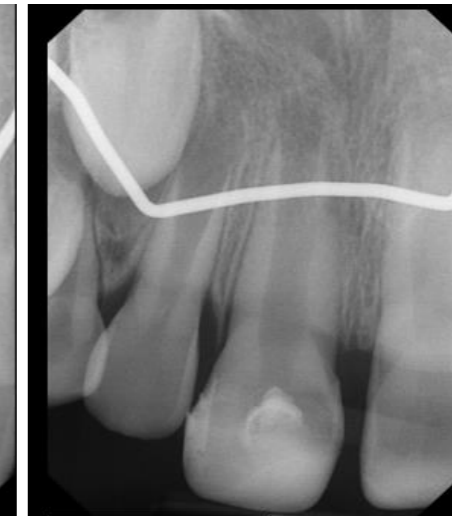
3-month post-op PA radiograph
